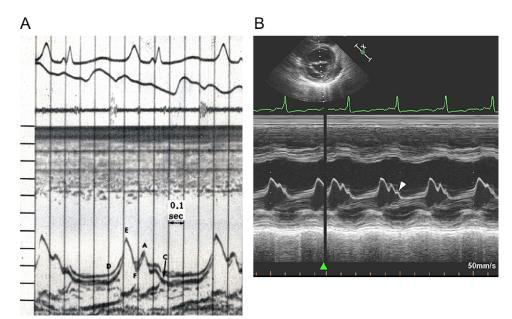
An old 2000 samples per second mitral valve M-mode recording (A) and a recent 1000 samples per second M-mode mitral valve recording (B) in patients with elevated LV end-diastolic pressure. (A, From Feigenbaum H. *Echocardiography*. 1st ed. Philadelphia, PA: Lea and Febiger; 1972.)
